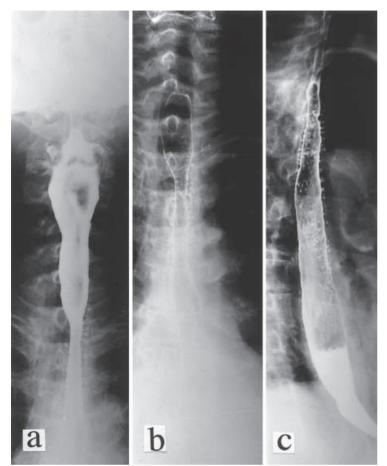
Radiography of the esophagus. a and b Filling and double-contrast esophagograms, showing dilated cervical esophagus with a distal 6-cm-long stricture. Protruding from this narrowed area are numerous small barium-filled projections. c Double-contrast esophagogram, demonstrating multiple diffuse tiny mucosal outpouchings, which are more apparent in the upper-to-middle thoracic esophagus
